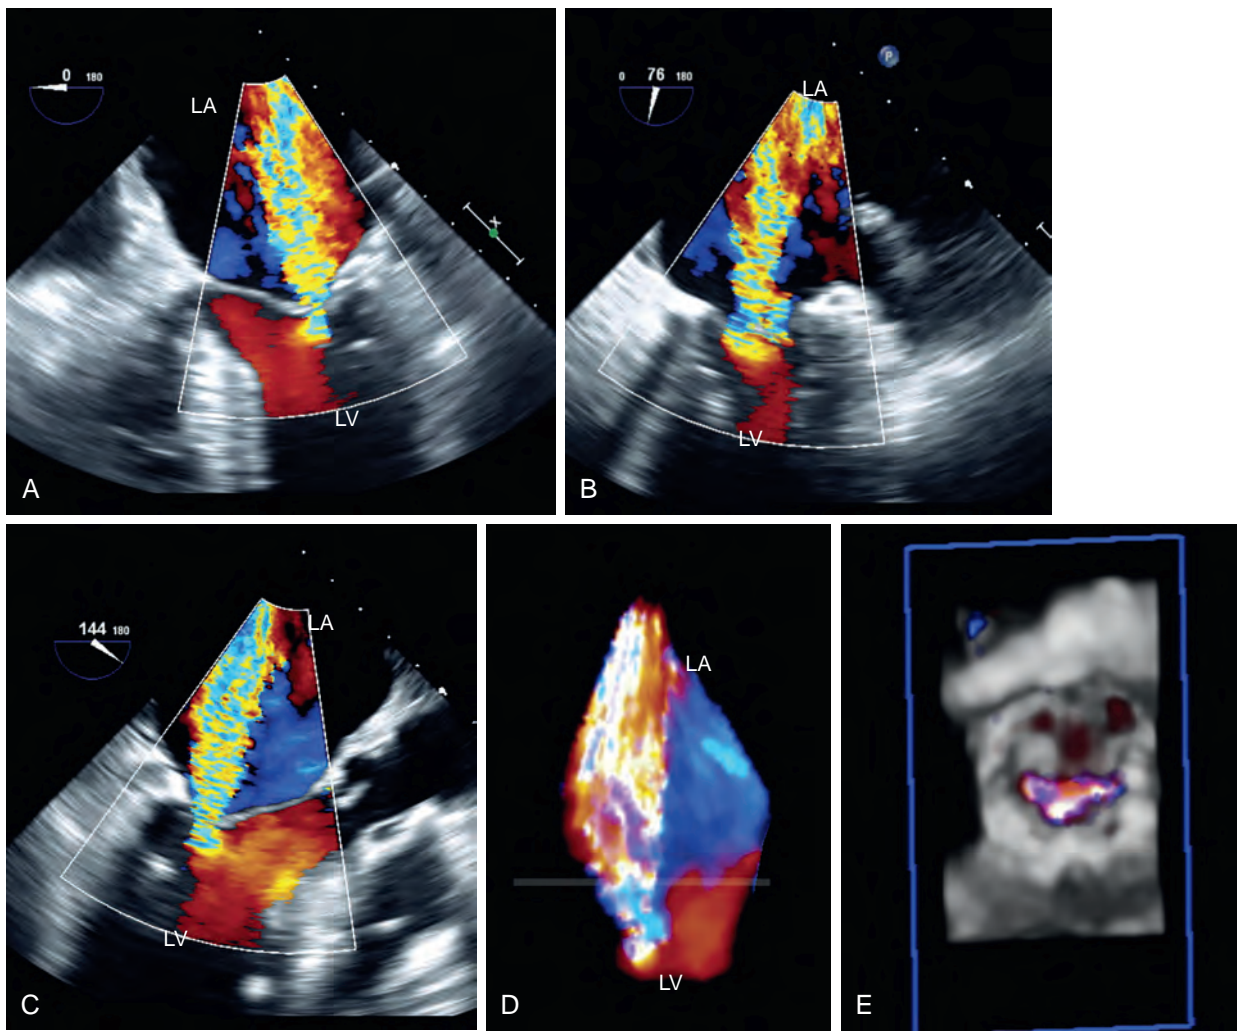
Assessment of mitral regurgitant (MR) jet. (A–C) Two-dimensional (2D) color Doppler views of a centrally directed MR jet. (D) and (E) Three-dimensional (3D) color Doppler assessment of the same regurgitant flow. (D) The MR jet on three levels (below, above, and at the level of the mitral valve) demonstrates the expansion of the regurgitant jet immediately after it passes through that regurgitant orifice (ie, entrainment). (E) Similar to Fig. 15.16, this shows an elliptical regurgitant orifice that is not similarly highlighted in the 2D color Doppler evaluations (A–C). Assumptions made regarding the shape of the MR jet, centrally or eccentrically directed, may not be accurate as evidenced by 3D imaging. Using 3D color Doppler imaging, planimetry of the regurgitant orifice area can be measured. LA, Left atrium; LV, left ventricle.
